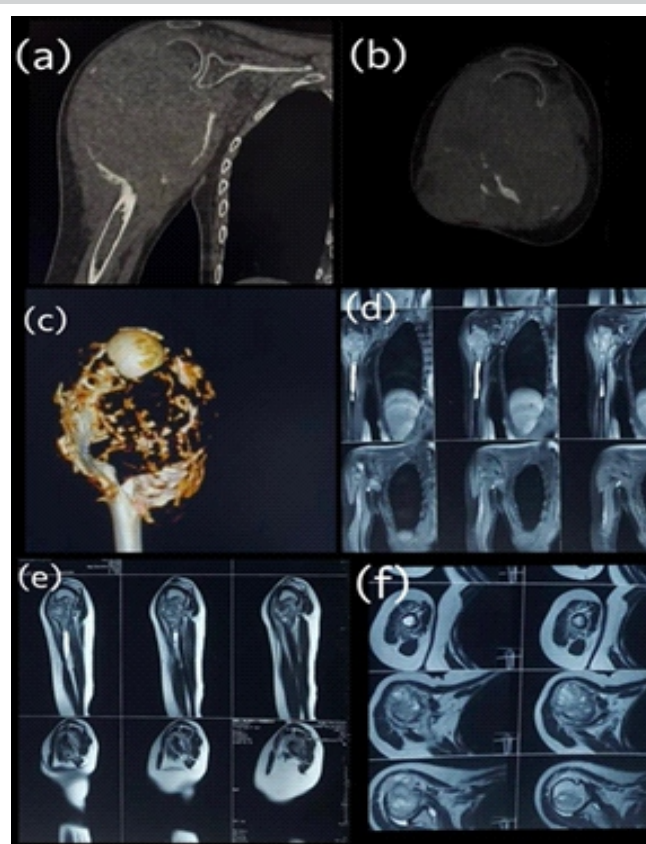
Pre-operative computed tomography (CT) scan. (a) Coronal CT image (b) sagittal CT image. (c) Three-dimensional CT reconstruction. Magnetic resonance imaging (MRI) of the right shoulder (d) coronal MRI image (e) sagittal MRI image (f) axial MRI image.
